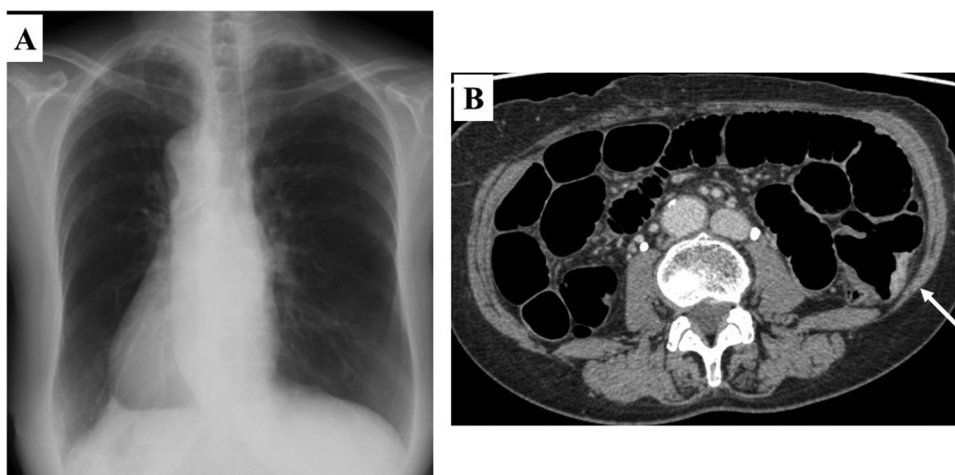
Chest radiography and abdominal computed tomography of the patient. (A) Chest radiography showing dextrocardia. (B) Abdominal computed tomography (CT) shows a mass in the ascending colon (arrow).
